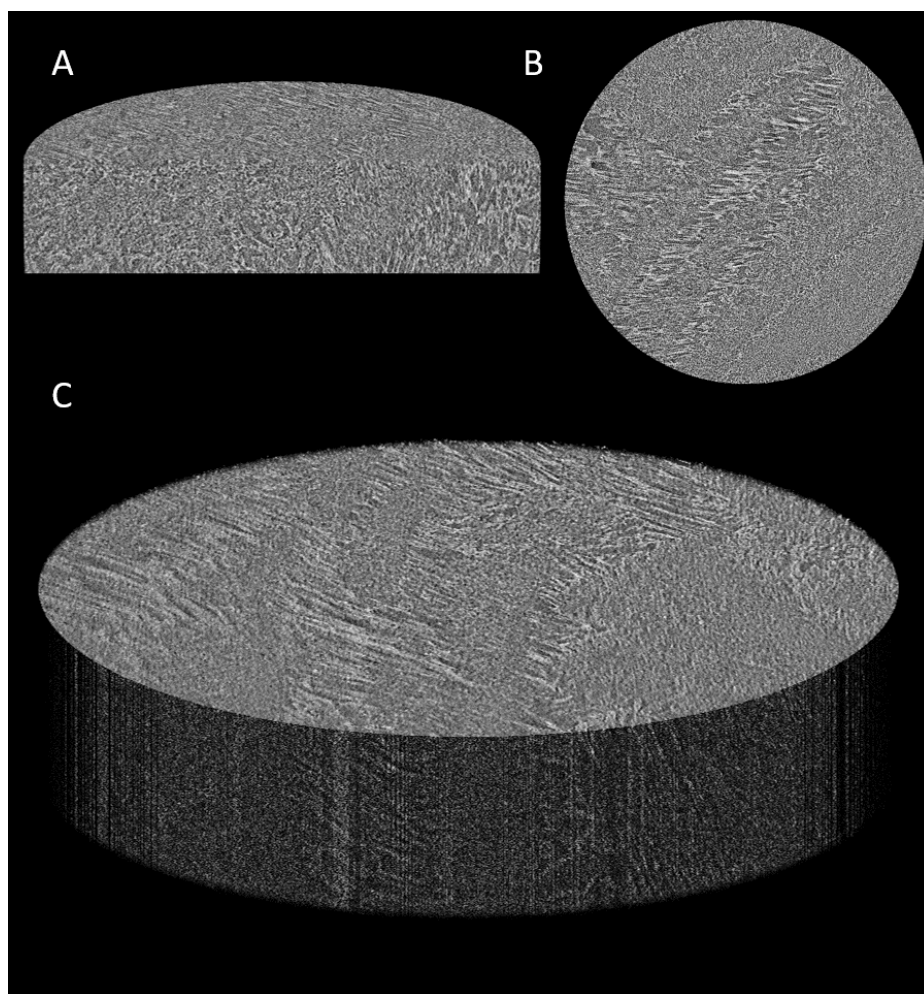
Micro CT scans of a 7.5% PVA aerogel showing (a) a three-dimensional representation of an orthogonal slice through the scanned section (b) a cross section of the scanned section of the gel and (c) a full three-dimensional representation of the scanned portion of the gel.
